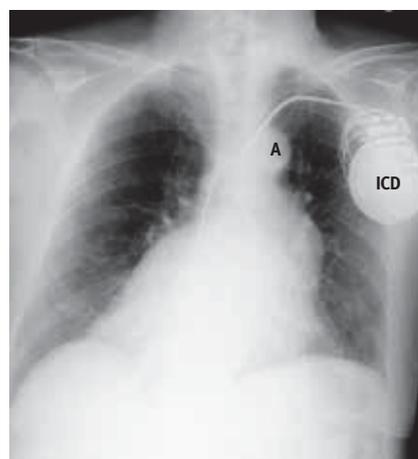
Chest X-ray demonstrating the heart in dextrocardia position along with the aorta in normal position and the implanted ICD
